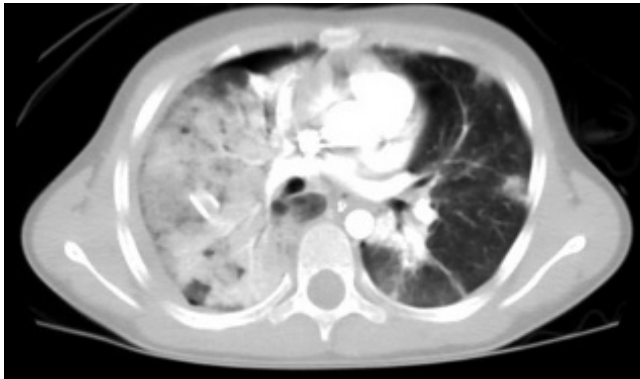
Six-year-old female pedestrian struck and pinned between two cars. Extensive pulmonary contusions are seen on chest CT.
